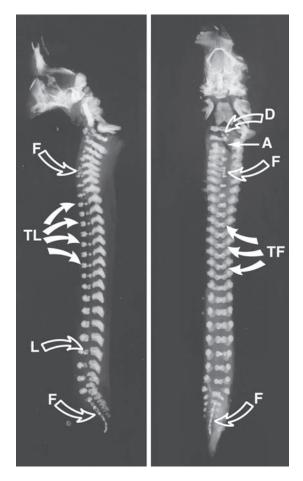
Radiograph of the vertebral column, 18-week fetus with trisomy 21. A, absence of cervical vertebral bodies; D, bifid vertebral body; F, fusion of adjacent vertebrae; TF, butterfly-shaped vertebral bodies; L malformed lumber vertebrae; TL, lateral view. (Keeling et al. 1997, with permission the *American Journal of Medical Genetics*.)
